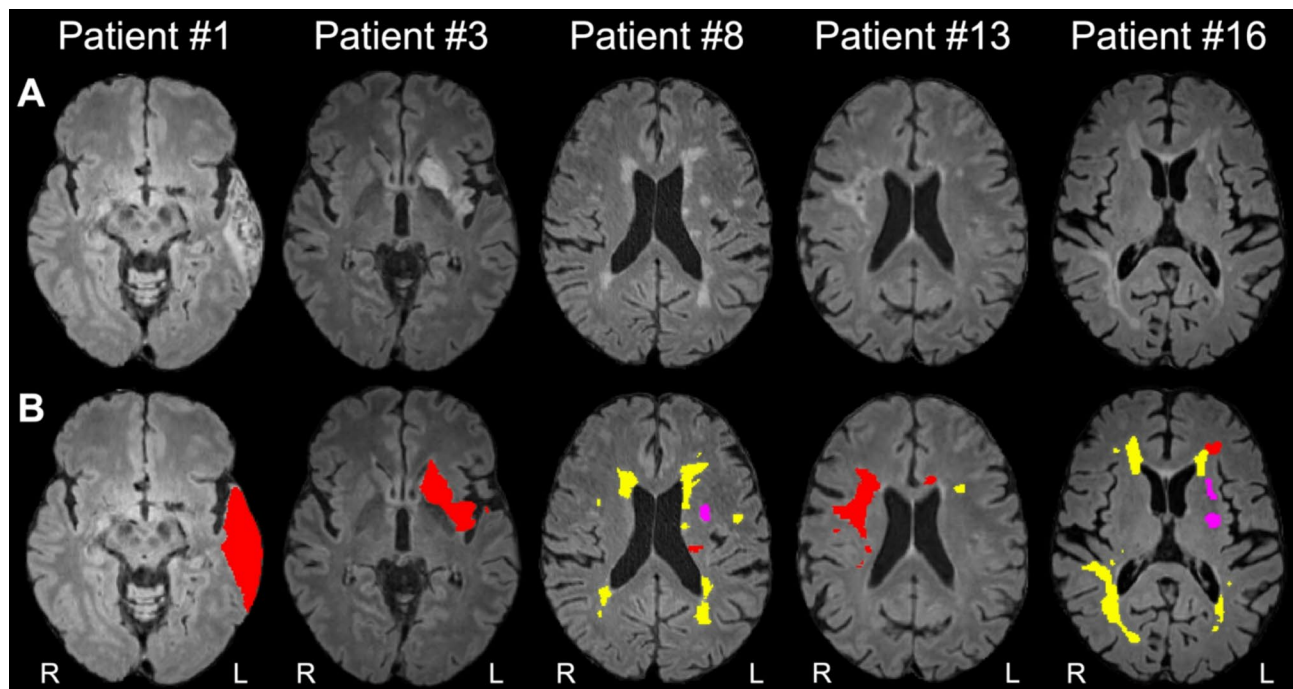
(A) T2-weighted FLAIR MRI image from five representative stroke patients (patient #1: 78-year-old male; patient #3: 69-year-old male; patient #8: 82-year-old male; patient #13: 84-year-old female; patient #16: 74-year-old male) at 6-months following stroke. (B) Manual segmentations of WM hyperintensities (yellow), index infarcts (red), and chronic infarcts (magenta) are shown overlaid onto FLAIR image. Index infarcts are identified as the infarct responsible for hospital admission (acute ischemic stroke). In patients #8 and #16, chronic infarcts are detected incidentally on FLAIR as covert or silent brain infarcts
